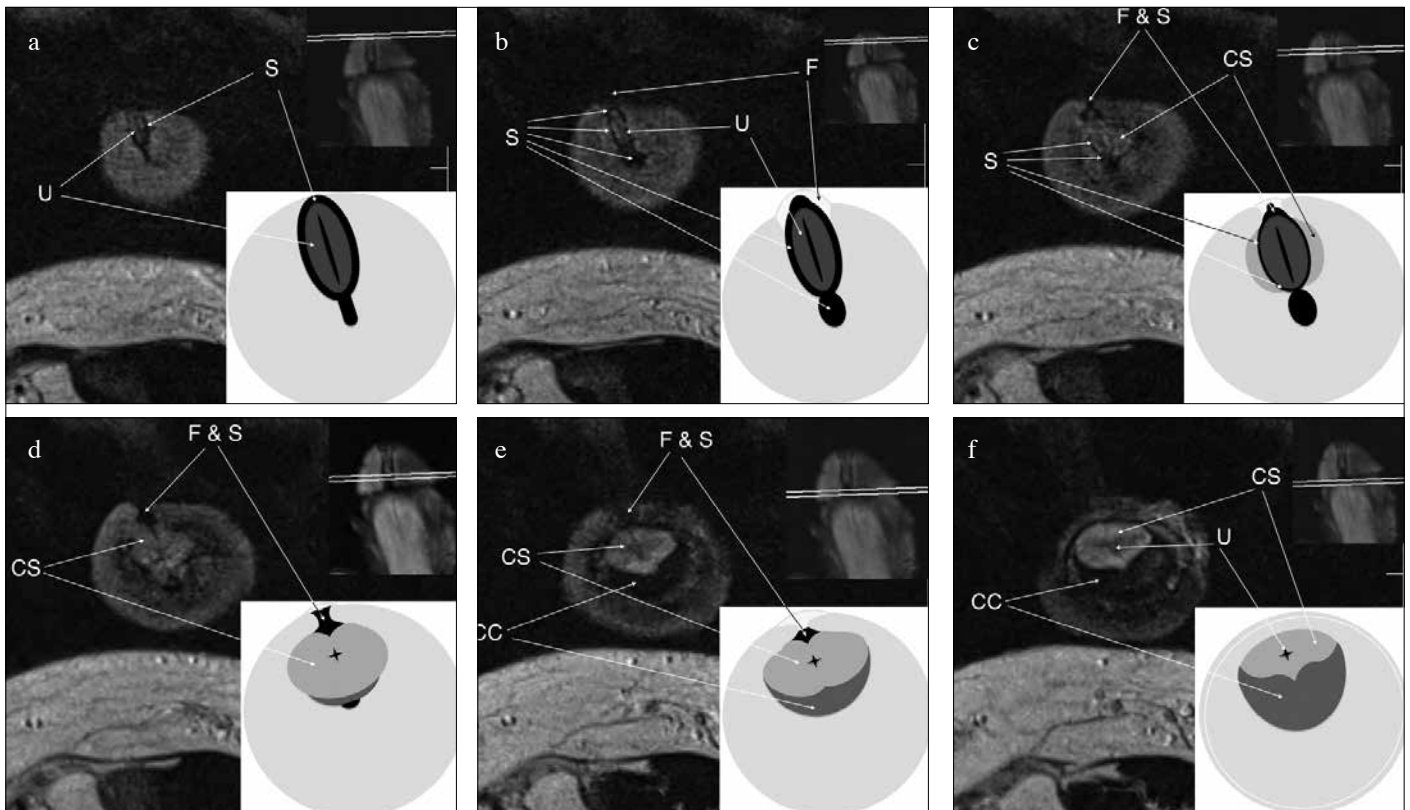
a-f. Cross sectional MRI anatomy of the glans penis in a 24 year old man, showing the fibrous tissue (septum glandis) between the glans wings (S). Note the walls of the glanular urethra as extension of the fibrous tissue connected to the frenulum (F), traversing the wings of the glans penis.
